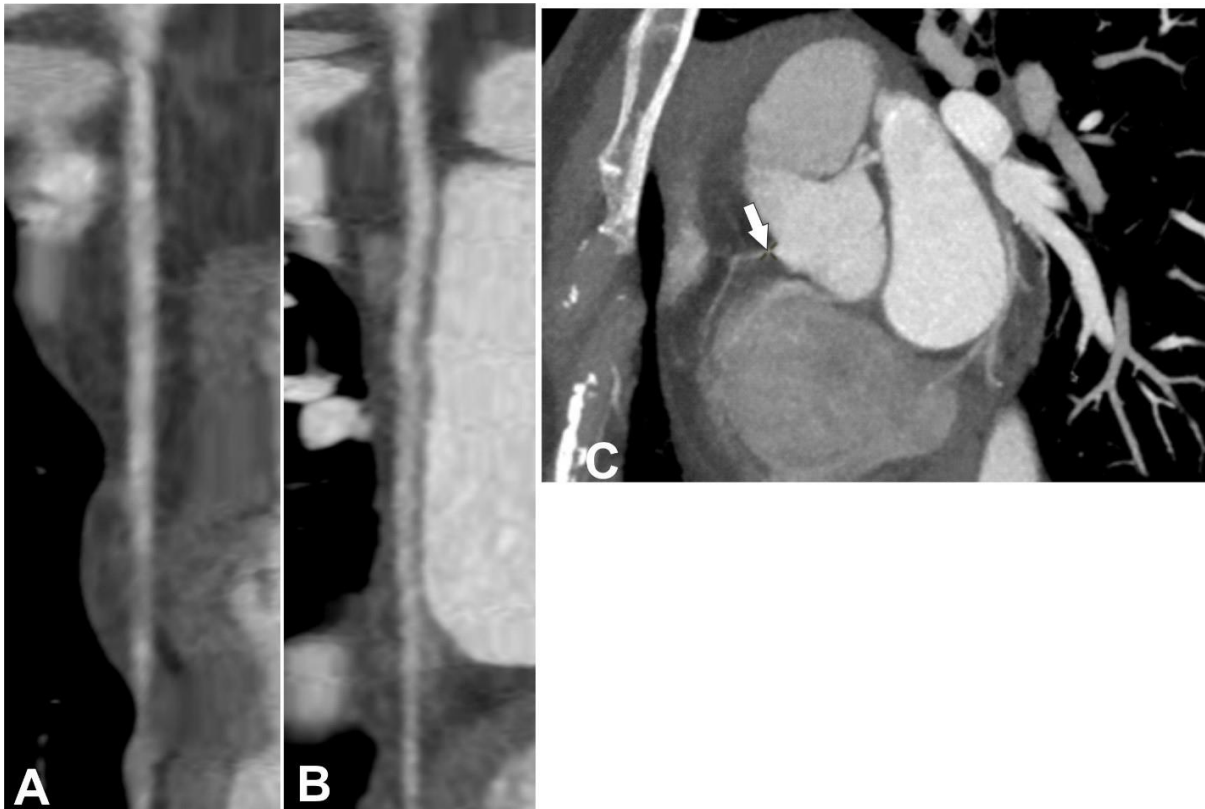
Coronary artery computed tomography angiography images. Curved multiplanar reformations along the vessel center line of left anterior descending artery (A), left circumflex artery (B) and hypoplastic right coronary artery (depicted with arrow, C).
